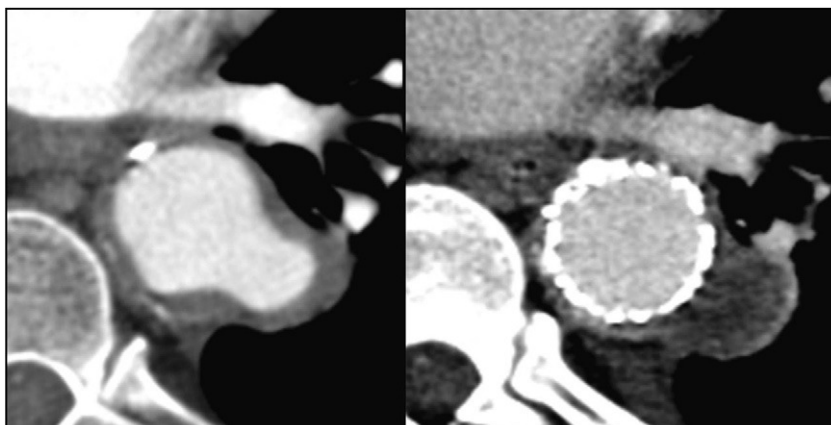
Exclusion of an aortic ulcer (pre- and postoperative computed tomographic angiography) in 2 different patients.
